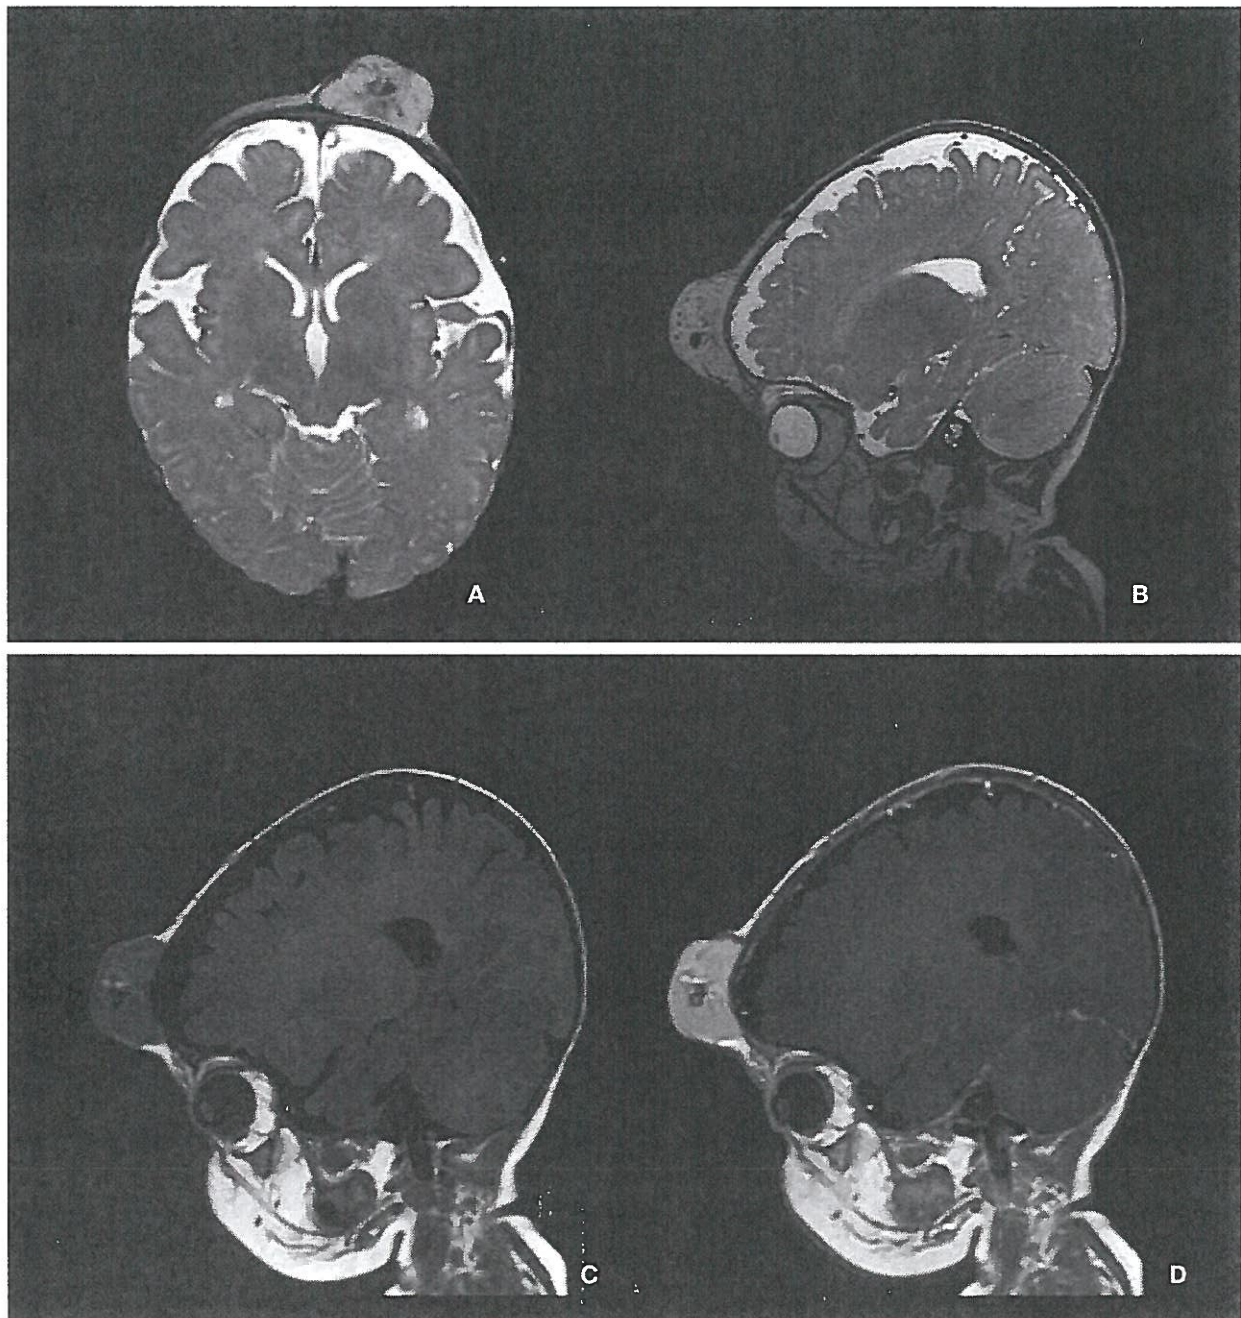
Hemangioma in 7-month-old girl with large soft tissue mass in forehead. Technique: head coil, 1.5 T, gadobutrol 0.6 mL by manual injection. Protocol: T2, T1, T1 Gd. Slice thickness 1.2–3.0 mm. Findings: 3 × 4 × 2 cm tumor attached to the bony calvarium on left side on T2-weighted images (A, B). Intermediate signal on T1 (C) with small spots of higher signal and small tubular hypointensities (signal voids) within the mass. After administration of gadobutrol, the tumor enhanced uniformly, except for central vascular structures (D). No obvious intracranial extension or other pathologic findings. Conclusions: MRI with gadolinium enhancement was valuable for determining the extent of disease and associated anomalies and for excluding malformations of the brain. Courtesy Dr E Stokland.
